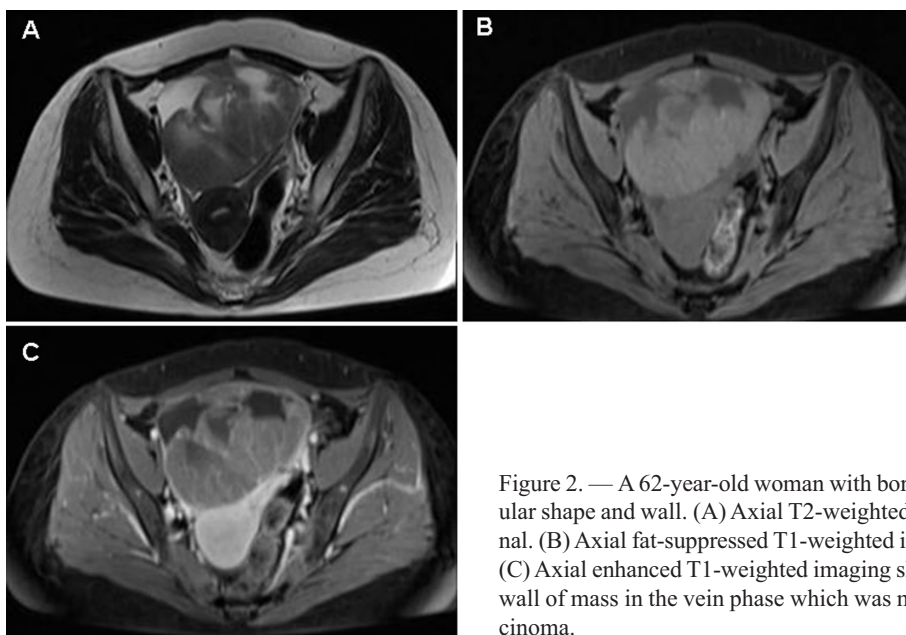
A 62-year-old woman with borderline mucinous cystadenoma with regular shape and wall. (A) Axial T2-weighted imaging shows high heterogeneous signal. (B) Axial fat-suppressed T1-weighted imaging shows low heterogeneous signal. (C) Axial enhanced T1-weighted imaging shows heterogeneous enhancement on the wall of mass in the vein phase which was misdiagnosed as mucinous cystadenocarcinoma.
